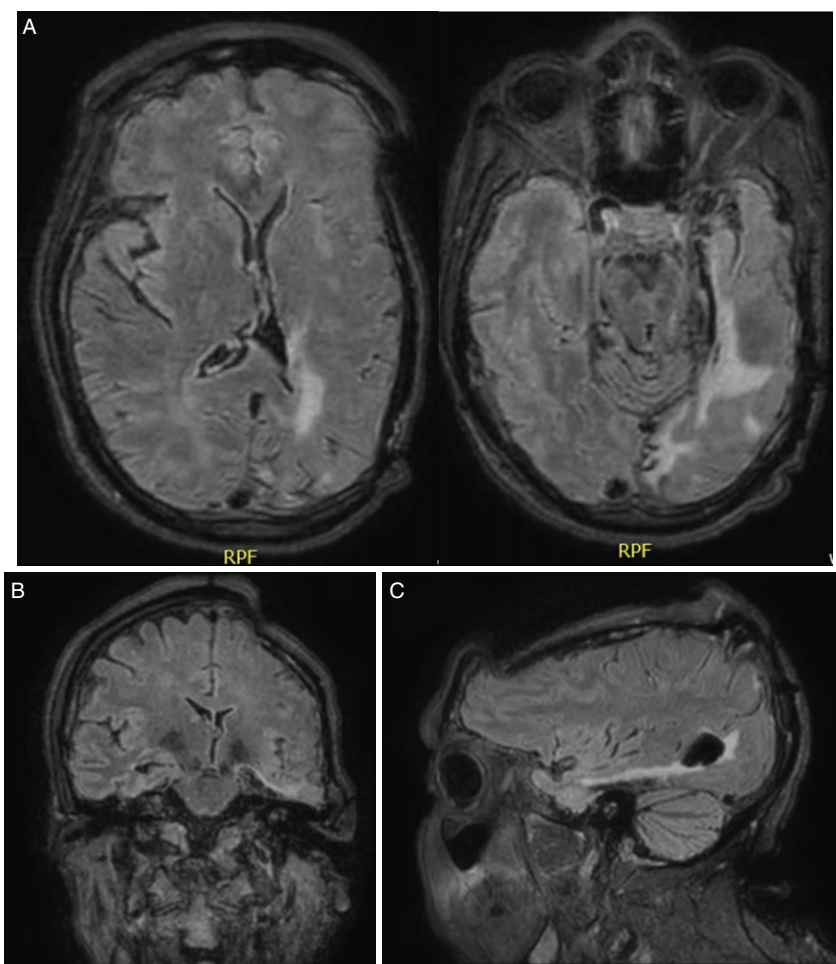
(A) Axial, (B) coronal and (C) sagittal FLAIR non-contrast MRI of the brain of a 39-year-old patient obtained at admission showing left temporal encephalomalacia, a sunken craniectomy flap, crowding of the quadrigeminal cistern and decreased volume of the left lateral ventricle suggestive of cranial hypotension.
